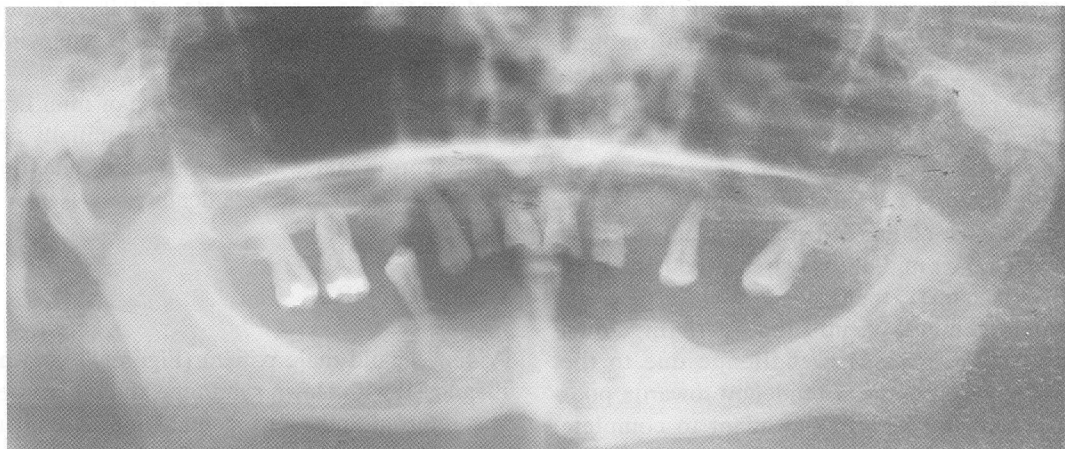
Panoramic radiograph taken at initial examination.
